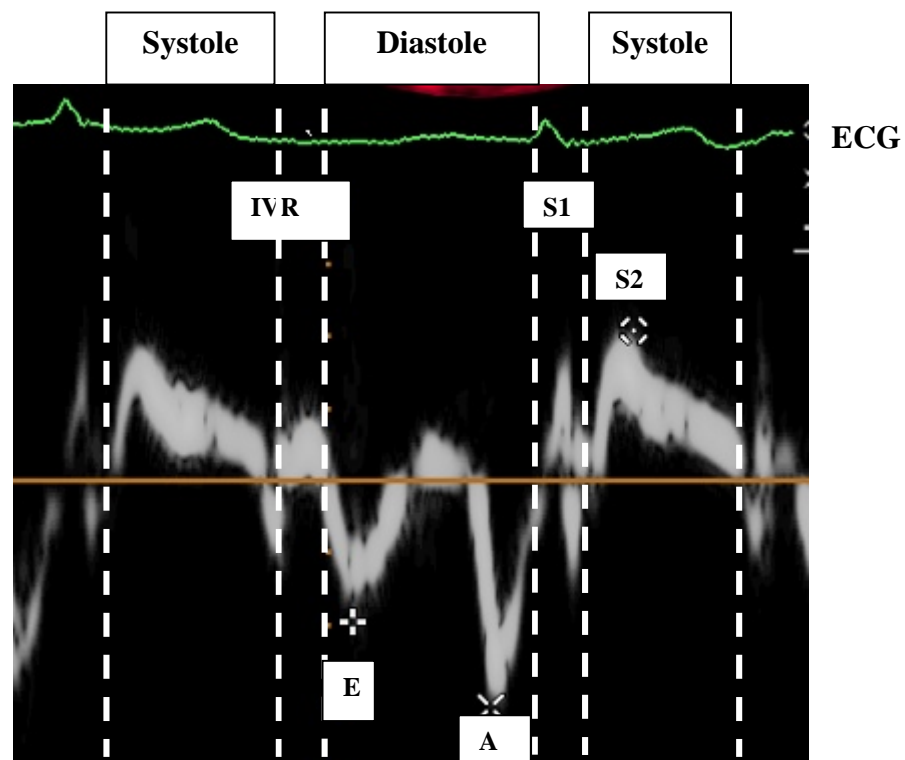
Longitudinal pulsed wave Doppler of the myocardium: S2= peak systolic wave, A= atrial contraction, E= Rapid filling, S1=isovolumic contraction (IVC), IVR=Isovolumic relaxation.
